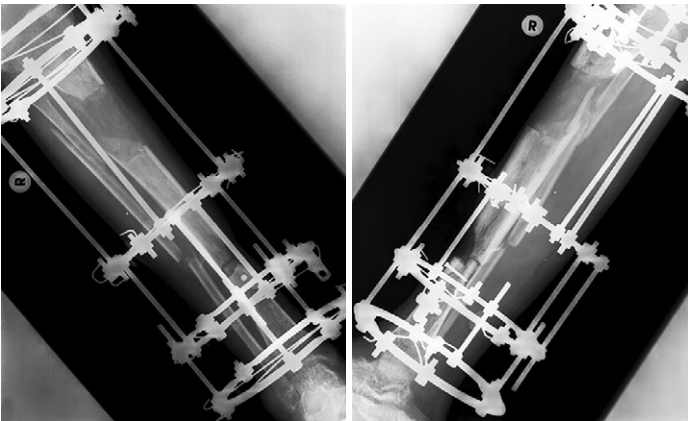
X-rays of the lower leg in frontal and lateral projections after restoration of limb length: maturing tibial regenerate
